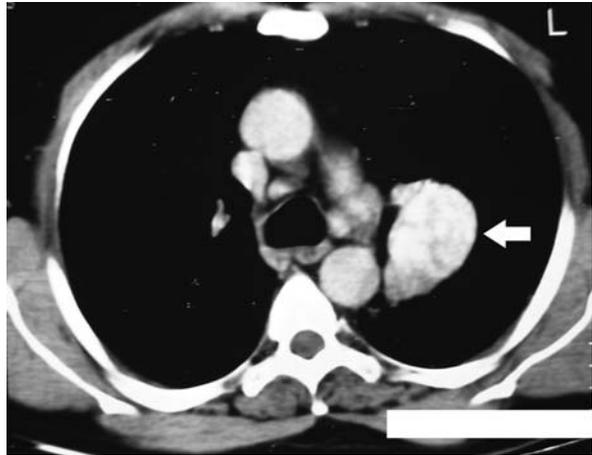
High-resolution computed tomography scan of the chest showing high-attenuation muroid impaction in a patient with allergic bronchopulmonary aspergillosis. Note that the density is far higher than the paravertebral skeletal muscles
